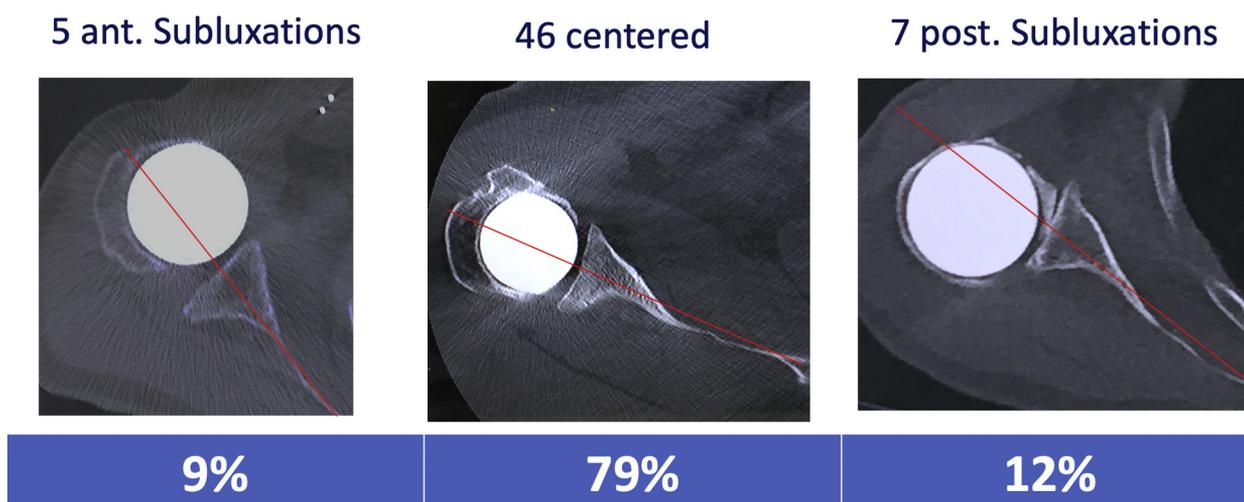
Axial computed tomography position of pyrocarbon interposition shoulder arthroplasty at last follow-up.
